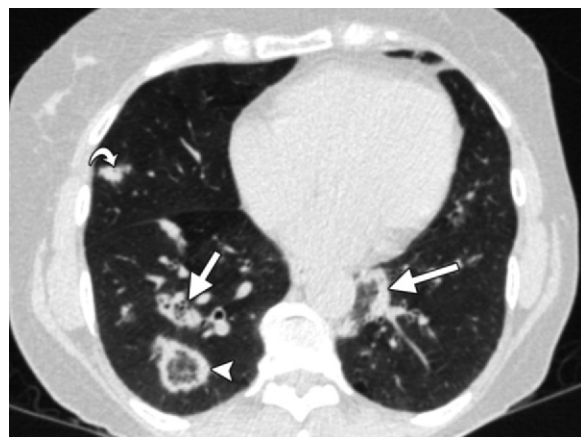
CT findings of COP. Axial image obtained in a 56-year-old woman shows multiple findings classically associated with OP, including the reverse halo sign (arrowhead) and the atoll sign (straight arrows). A 9-mm nodule is seen in the right middle lobe with an internal air bronchogram (curved arrow). Although this type of nodule can be seen with various pathologic processes, additional CT findings of OP can help confirm the diagnosis.
